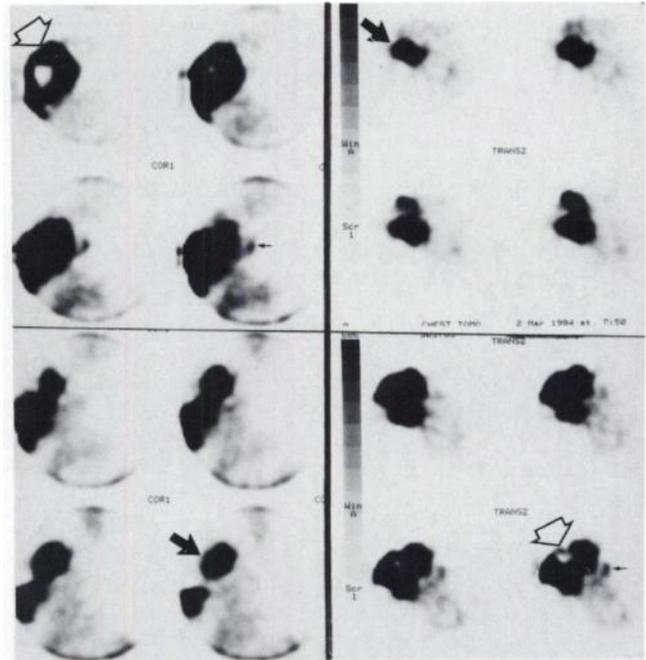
Selected coronal (left) and axial (right) chest SPECT images show a large active lymphoma in right breast (open arrows) with central necrosis and metastases to right axillary (closed large arrows) and internal mammary nodes (small closed arrows).
